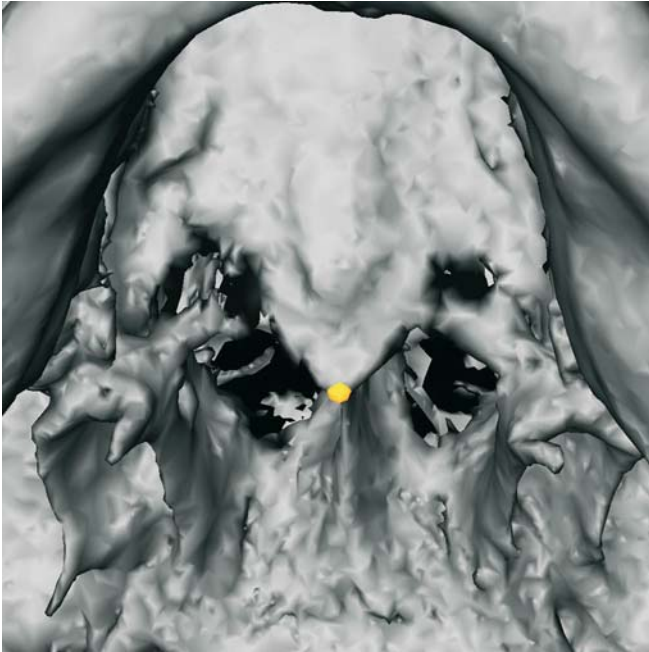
Posterior nasal spine. Exocranial skull base view (3-D CT, patient K.C.)
